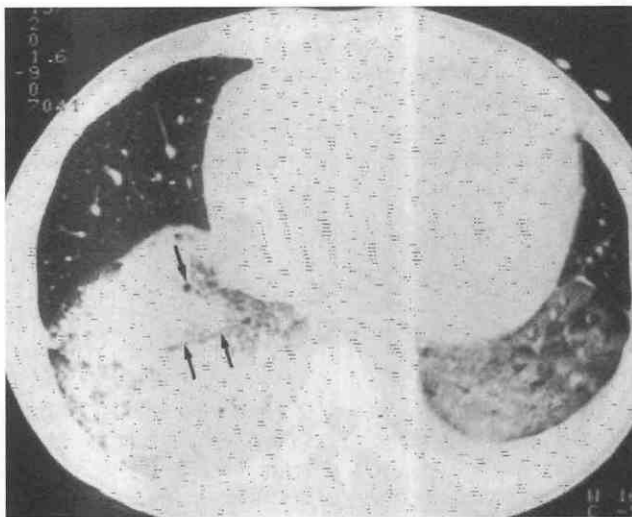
Multilobar pneumonia. Air-bronchograms are a hallmark of air space disease on CT scans, as they are on plain films. (From Kuhlman JE: CT of diffuse lung disease. Appl Radiol 20:17-21, 1991.)
